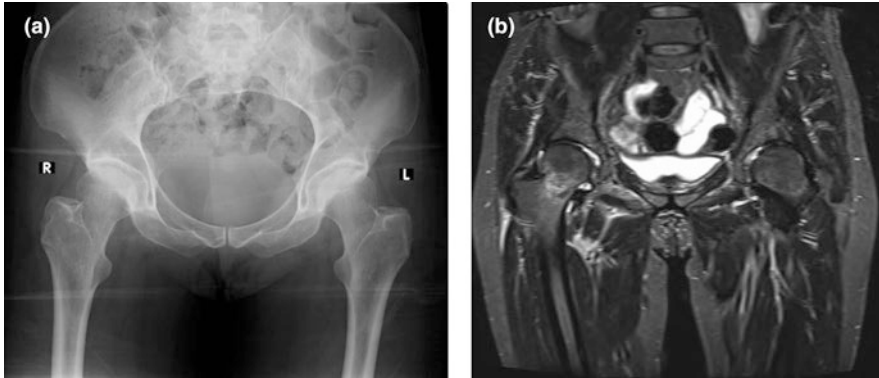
Pelvic radiograph (a) appears normal, but MRI (b) shows an occult right sided neck of femur fracture
